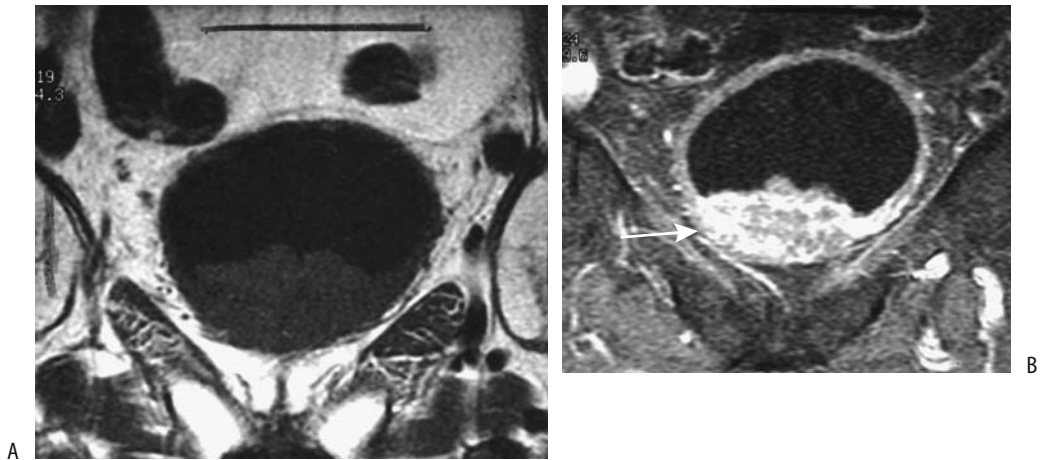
Bladder carcinoma. Coronal T1-weighted (A) and contrast-enhanced (B) MR images reveal a mostly intraluminal, heterogeneous tumor (arrow). (Source: Burgener FA, Meyers SP, Tan RK, Zaunbauer W. *Differential diagnosis in magnetic resonance imaging*. Stuttgart: Thieme, 2002, with permission.)
